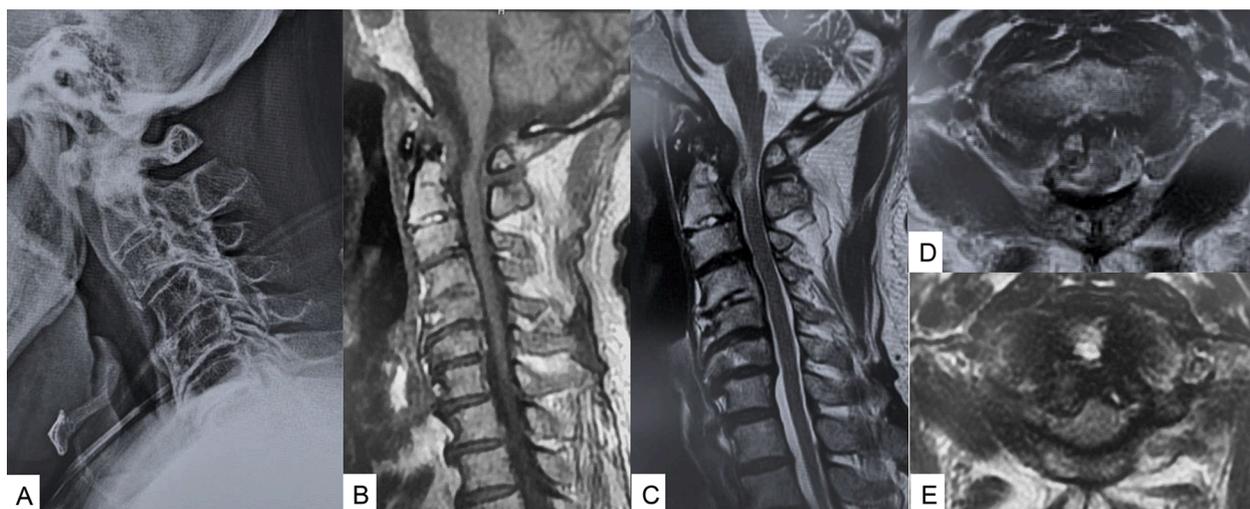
Preoperative radiograph and MRI A) Lateral radiogram in flexion. B) Mid sagittal T1 weighted image. C) Mid sagittal T2 weighted image. D) Axial T1 weighted image at C1 E) Axial T2 weighted image at C2.
